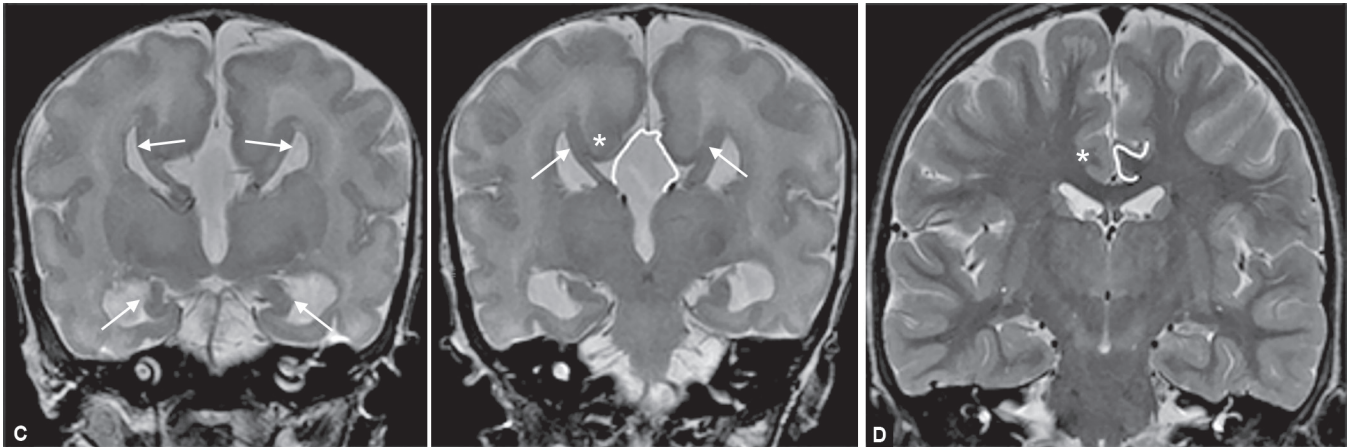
(A) Coronal transfontanellar ultrasound images of a neonate with complete agenesis of the corpus callosum (CC). No commissural fibers of the CC are noted to cross the interhemispheric fissure (the "X" marks the area where the missing CC would have been seen). In addition, the lateral ventricles are lateralized (marked by laterally pointing white arrows) and the anterior horns of the lateral ventricles nearly mimic a Texas longhorn configuration (shown above, horn-like appearance marked by asterisks, \*); (B) Colpocephalic-widening of the occipital horns of the lateral ventricles (arrows)
